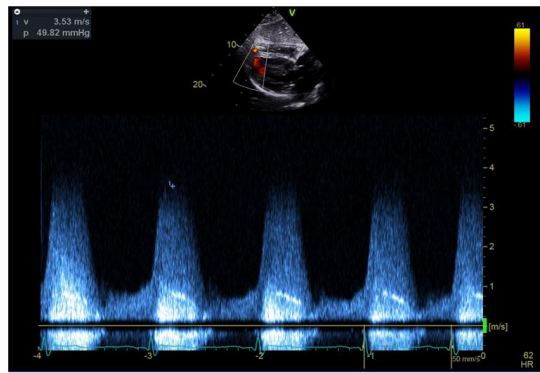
Transthoracic echocardiogram subcostal view revealed a left to right shunt with peak grad 49 mmHg.
